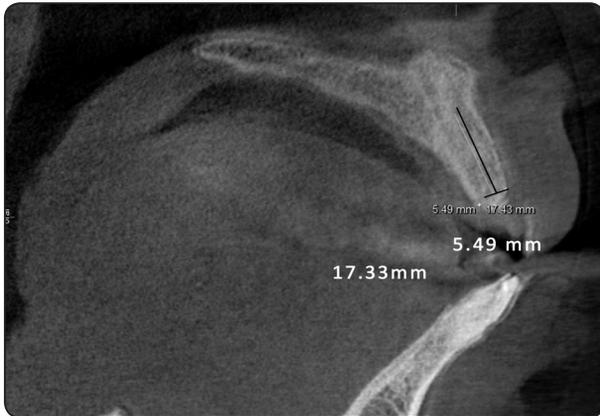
sagittal cut on (CBCT) show measurement of bone height and width
